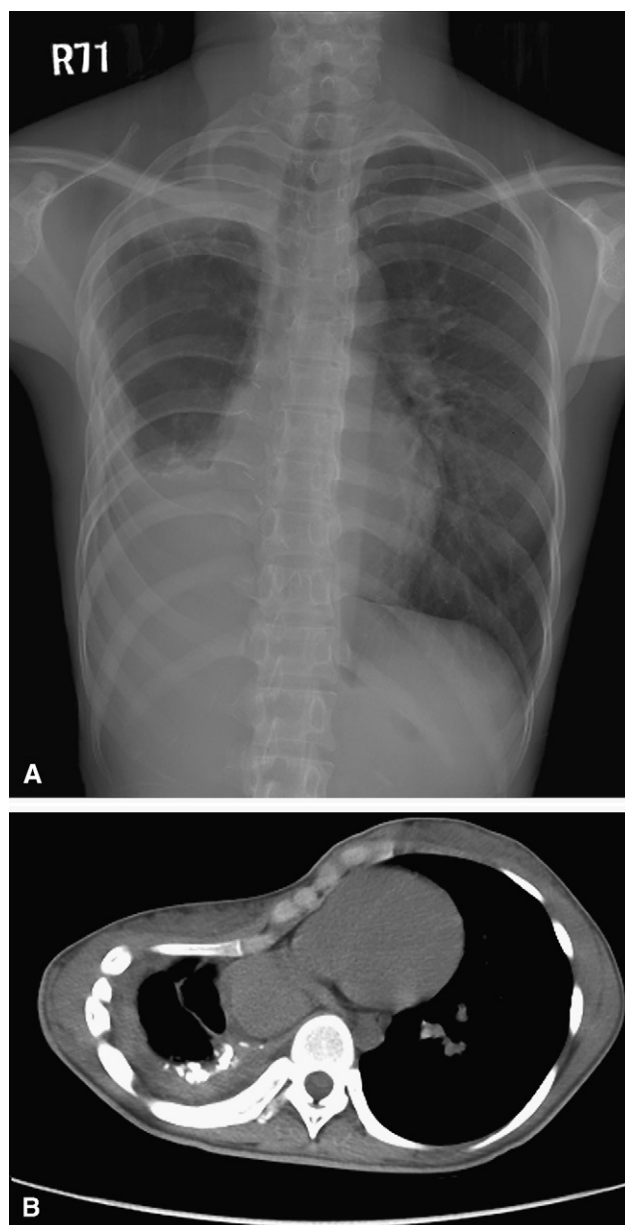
A, Chest x-ray film shows limited right lung volume and pleural thickening before the Nuss operation. B, Computed tomographic scan of the chest shows calcified pleural plaques at the right basal thoracic cavity and severe asymmetric depressed pectus excavatum.
